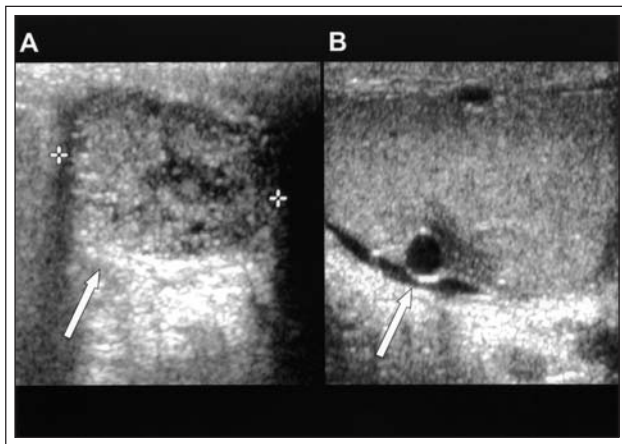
Scrotal Ultrasound. (A) 2.2 cm heterogeneous nodule, separate from the testicle and found to be a paratesticular Schwannoma. (B) Crescentic zone of decreased echogenicity along the posterior aspect of the testicle with cystic changes and calcifications, determined to be benign testicular tissue by pathology.
